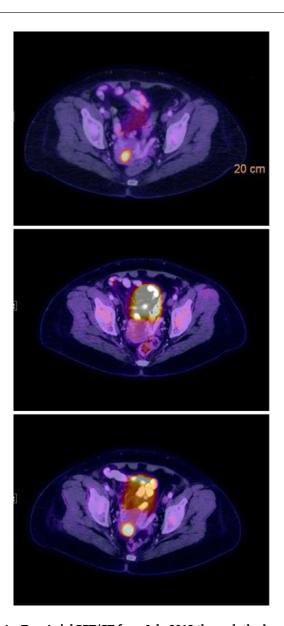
Top: Axial PET/CT from July 2013 through the level of the uterus demonstrates a hypermetabolic focus within the uterus.
